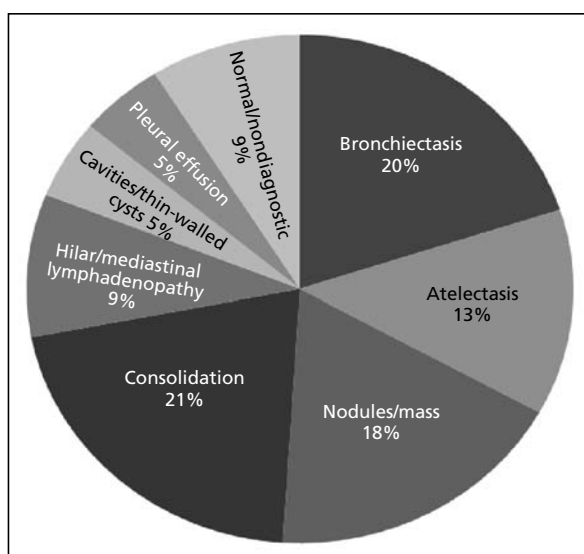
CT findings in patients with haemoptysis.
